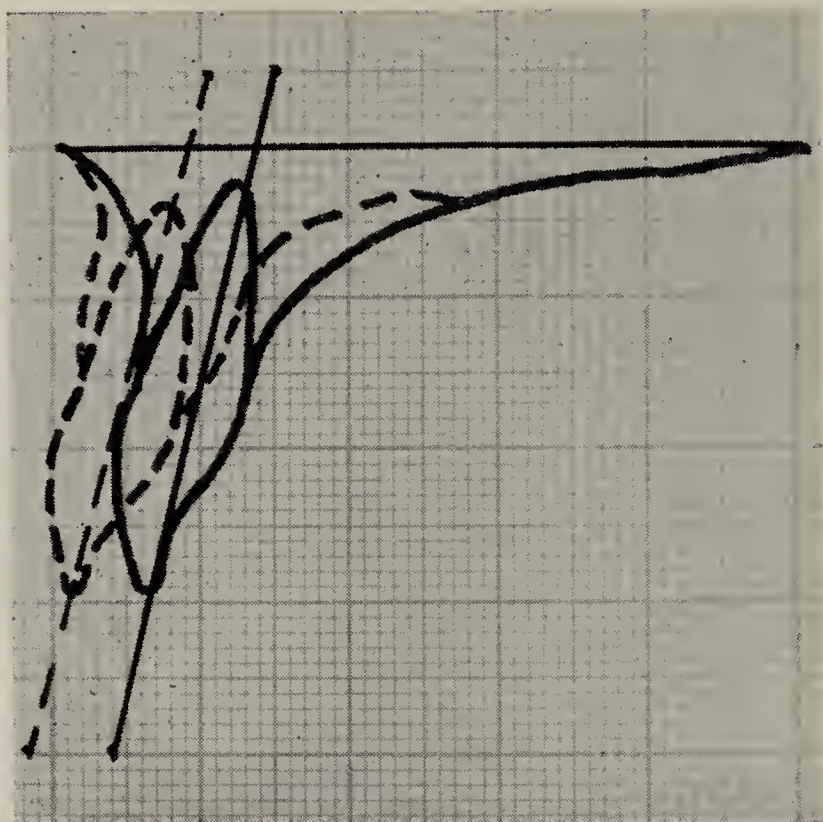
Case 1. A, Apical change 4 mm. Crown change 3 mm. Dotted outline the original position. Solid outline the ultimate position. B, Radiographs before and after treatment.
